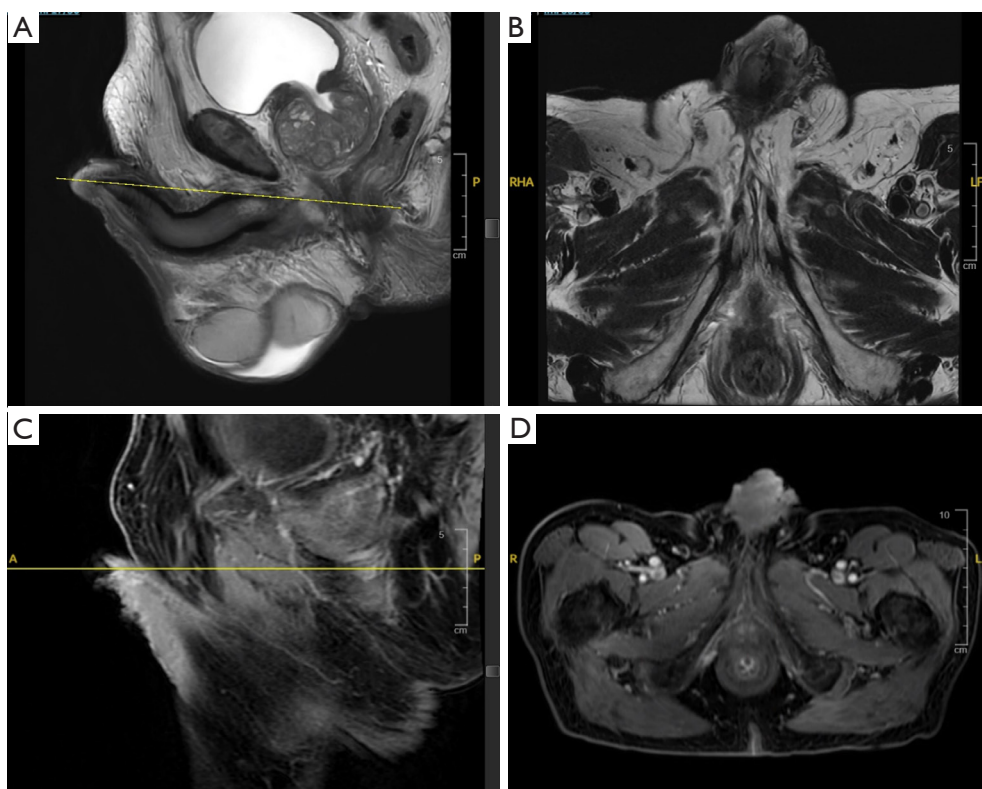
One-year postoperative MRI penile mass protocol including (A) sagittal T2 and (B) axial T2, and with IV contrast [(C) sagittal and (D) axial] confirmed no evidence of residual, recurrent disease or abnormal inguinal or pelvic lymphadenopathy. MRI, magnetic resonance imaging.
